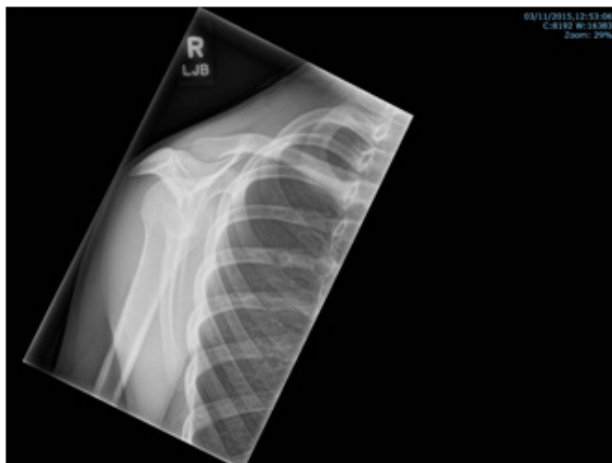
Plain lateral radiograph of right shoulder obtained at initial presentation.
